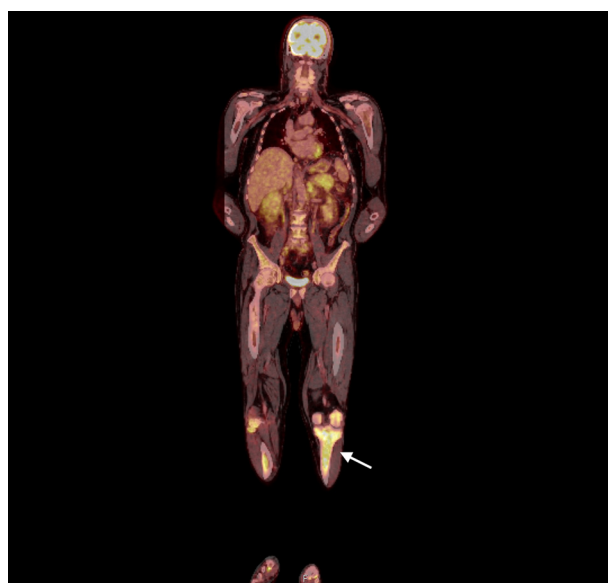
In the PET-CT scan, there was diffusely markedly increased tracer uptake in the distal femur, tibia, and tarsal bones bilaterally, with an SUVmax up to 6.0, indicating significant skeletal involvement.
